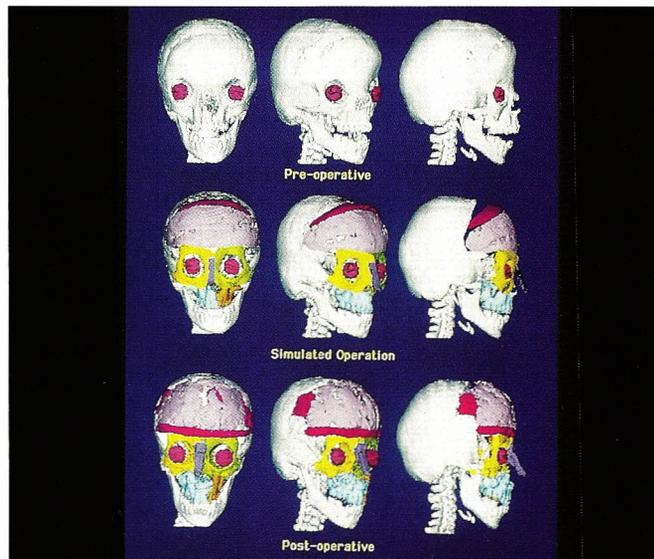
Craniofacial Surgical Planning and Evaluation. Interactive software on desktop workstations is used to plan and evaluate craniofacial surgical procedures. Volumetric CT data are received via an electronic network and visualization software allows display of the 3-D data. Top row shows the preoperative views of the skull in a child with hypertelorism. The ocular globes have been isolated and are displayed within the orbits. The middle row shows the result of surgical planning, performed interactively by a surgical research fellow. The bottom row was created from post-operative scans to validate the surgical planning operations and test the quality of this process. (Courtesy of Surgical Planning Laboratory, Brigham and Womens Hospital, Boston, Mass. and GE Medical Systems, Inc.)
